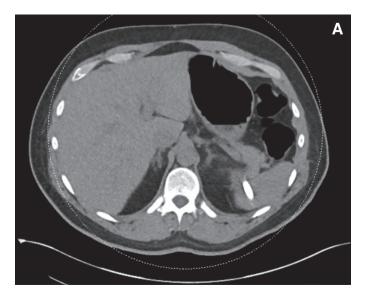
Colonic perforation. (A) CT—colonic perforation by percutaneous nephrostomy tube. (B) nephrostogram demonstrates colorenal fistula.
